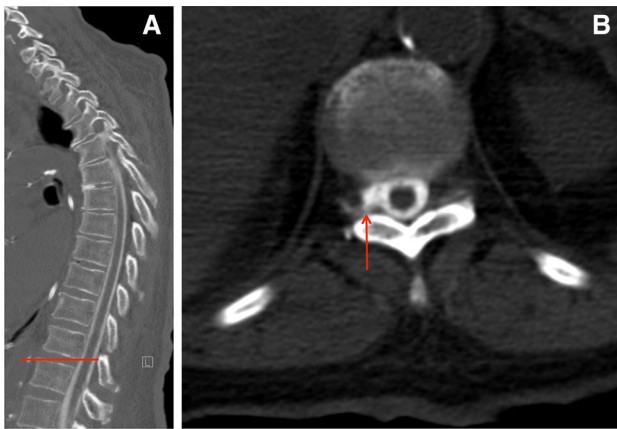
CT myelogram. a Sagittal view shows level (*line*) of axial cut. b Axial view showing CSF extravasations (*arrow*)
